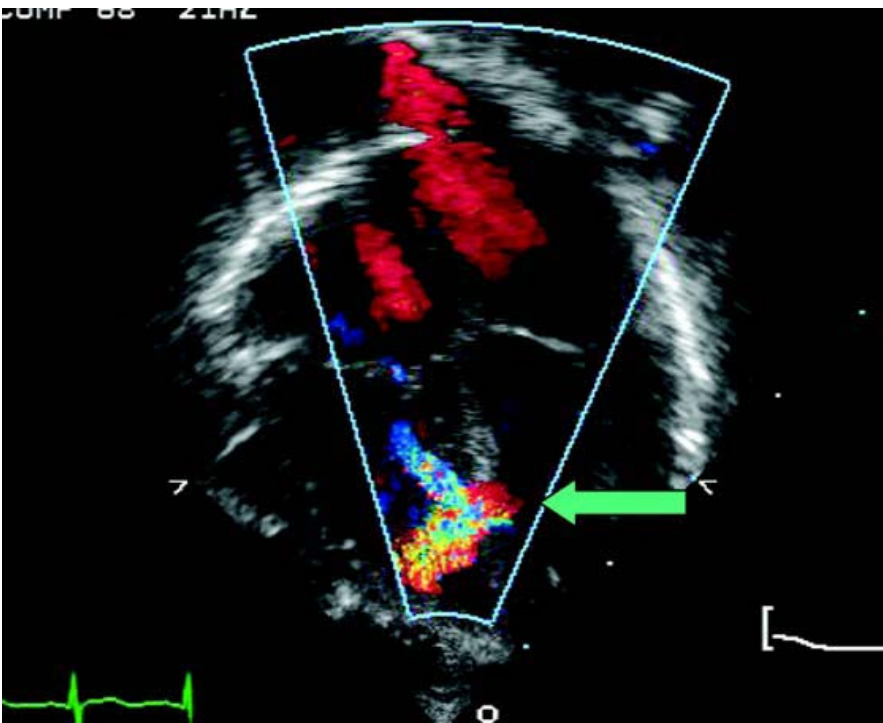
Echo colour Doppler of a muscular VSD with 4-chamber scan.
